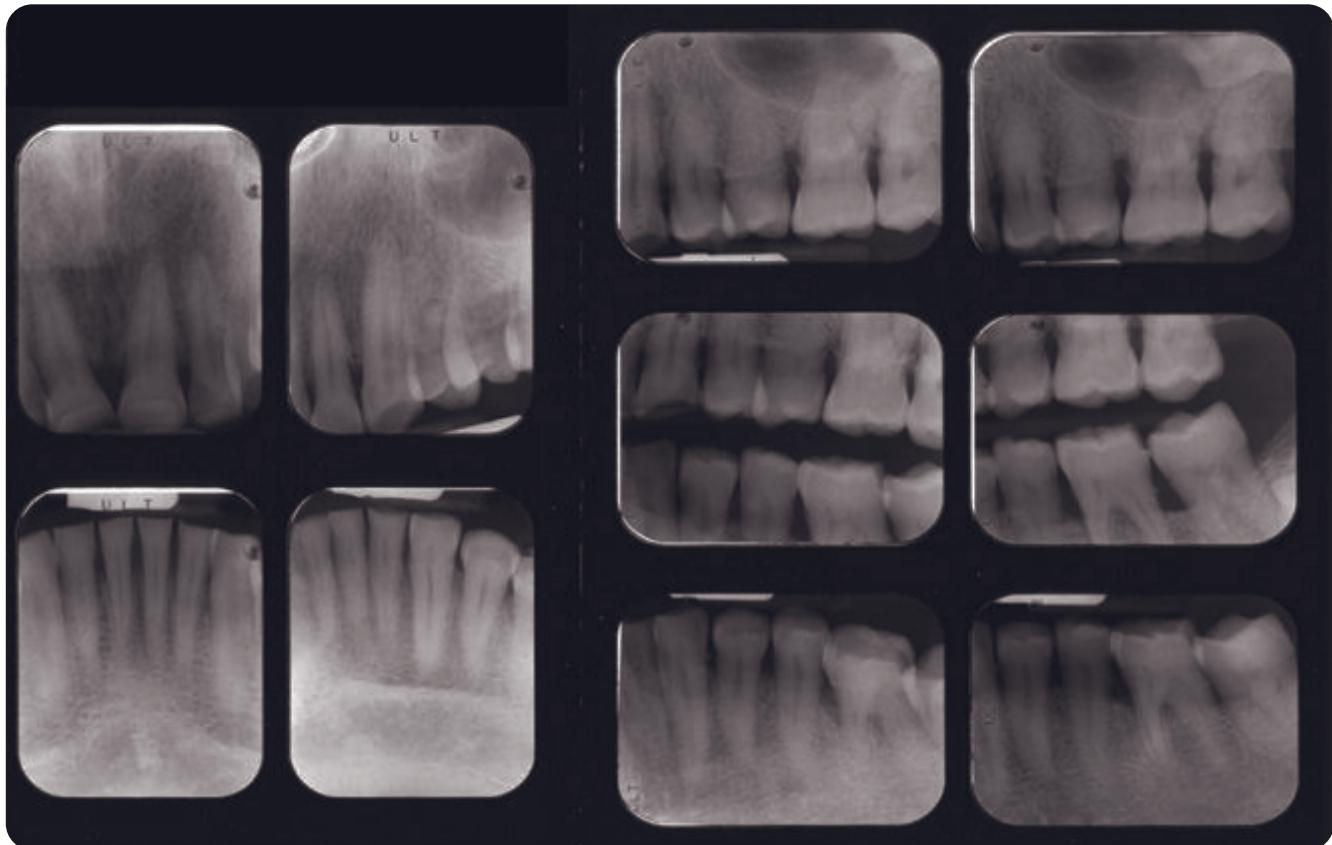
Pretreatment radiographs, left side.
